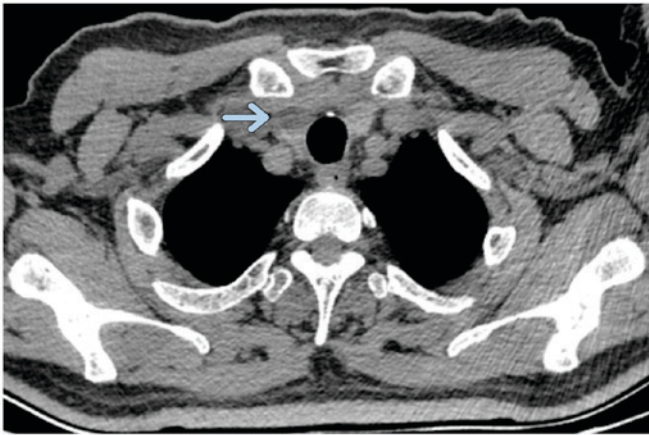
A computed tomography scan indicated a low-density mass in the right lobe of the thyroid posterior to the clavicle (arrow).
